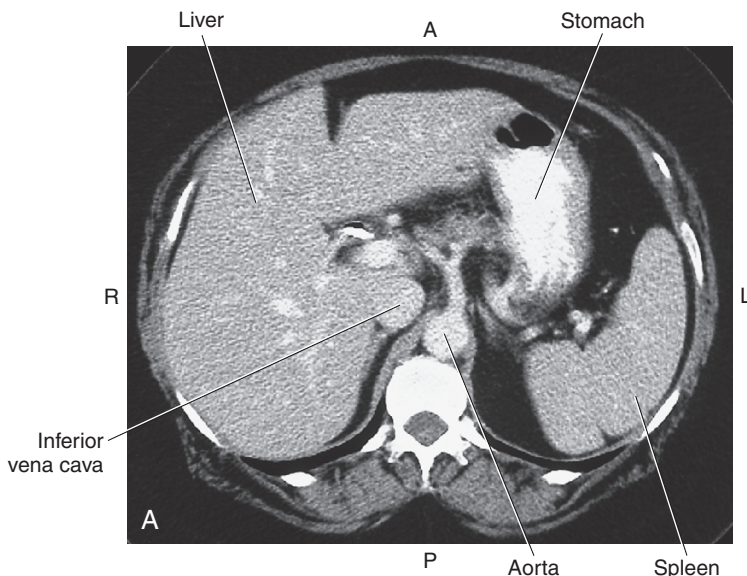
(A) Axial CT of abdomen. (B) 3D CT of pelvis (anterior view).
